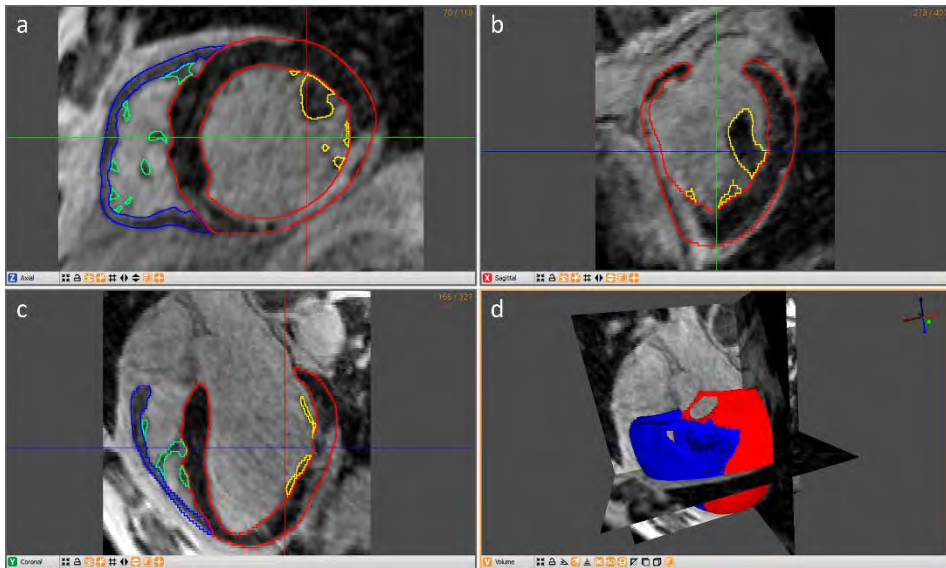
Manual segmentation process of cardiac DE-MRI slices performed with Seg3D. Contours highlighted in distinct colours show the different cardiac structures segmented independently: LV myocardium including the septum (*red*), RV myocardium (*blue*) and papillary muscles and endocardial trabeculations of LV (*yellow*) and RV (*green*). The four panels show segmented slices of the DE-MRI stack in different cardiac planes: (a) short axis, (b) long axis or two-chamber view, (c) four-chamber view and (d) rendering of the isosurfaces generated from segmentations (LV in *red* and RV in *blue*) displayed on an anterior 3D view of the orthogonal cardiac planes.
